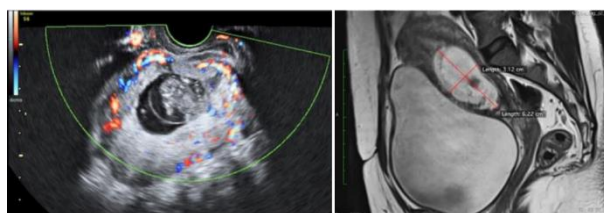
Color Doppler showing increased vascularity and MRI film showing anterior myometrial thickness $<2 \text{ mm}$
